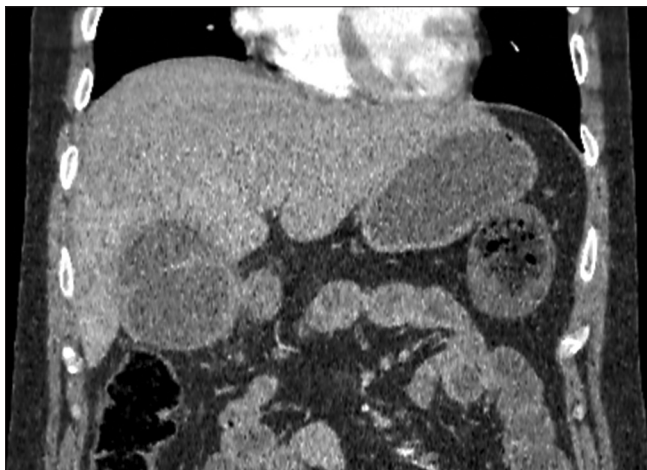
Computed tomography image of the abdomen
